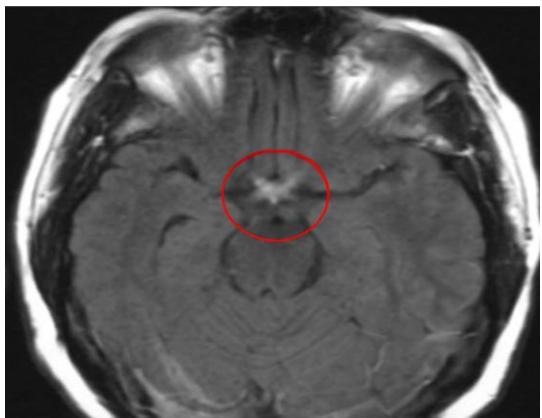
MRI of brain and orbit was suggestive of demyelinating changes in bilateral posterior optic nerves near optic chiasma and pons.
